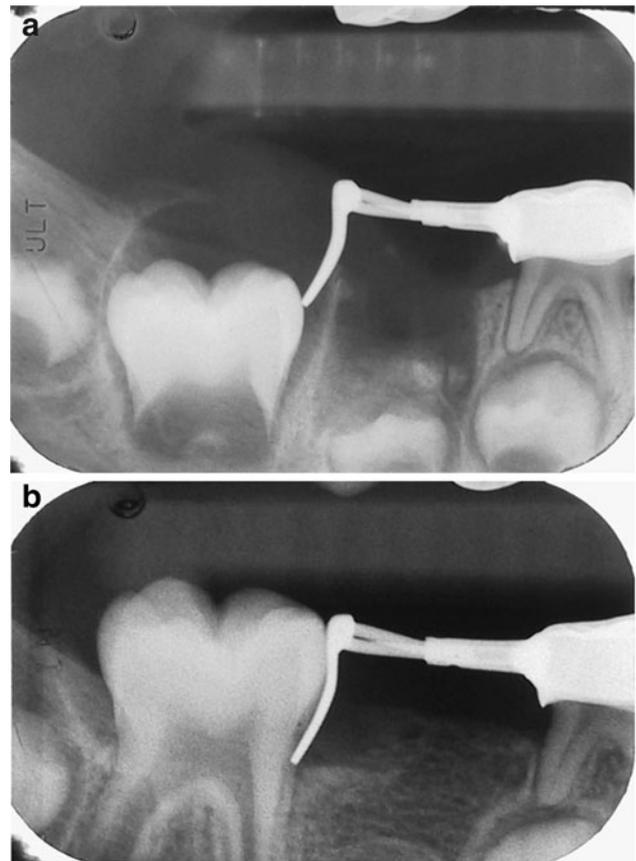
Radiographs demonstrating placement of band and distal shoe space maintainer (BDSSM): a taken immediately after BDSSM is cemented into place with optimal fit to the mesial marginal ridge surface of the permanent first molar tooth, and b 2 years post-operative with the permanent first molar erupted into an ideal position
